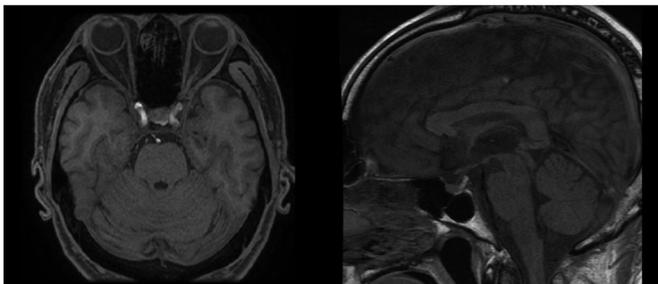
T1-weighted sagittal pituitary magnetic resonance imaging showed no abnormalities in the size or shape and no nodular structure.
